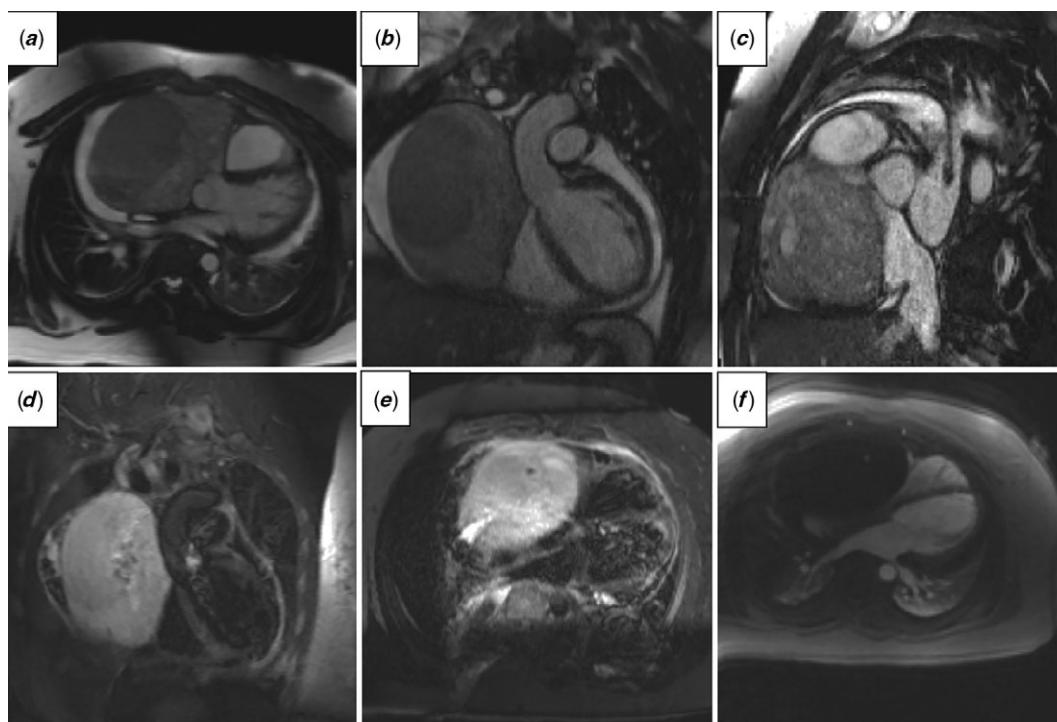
(a–c) Balanced steady-state free precession sequence shows large heterogeneous mass compressing right atrium and right ventricle (a–c) and extending to the aortic root (b). (d and e) T2-weighted TSE images show hyperintense mass. (f) Rest perfusion revealed hypoperfusion of the mass compared to the normal perfused myocardium indicating low vascularity.
